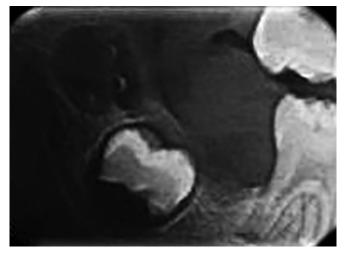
Intraoral periapical radiograph of the lesion showing resorption of alveolar crestal bone and radiolucency occlusal to 47 tooth bud
